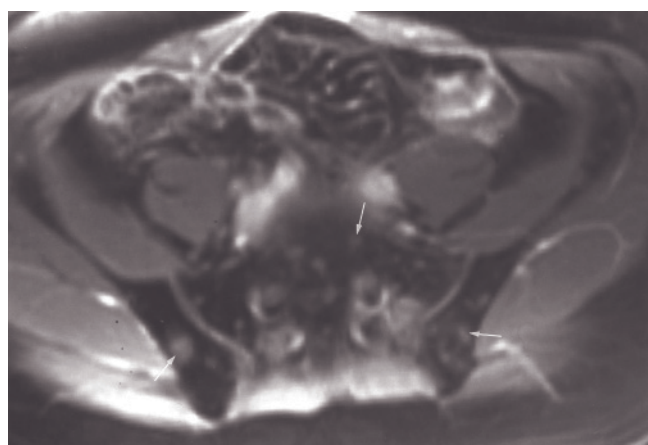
Recurrent rectal adenocarcinoma invading sacrum. Sagittal T1-weighted SGE (*a*), sagittal 512-resolution T2-weighted fat-suppressed echo-train spin-echo (*b*), and oblique coronal postgadolinium fat-suppressed SGE (*c*, *d*) images. A large recurrent tumor mass invades the sacrum and is intermediate in signal intensity on the T1-weighted image (arrow, *a*) and heterogeneously high in signal intensity on the T2-weighted image (arrow, *b*). After contrast the tumor enhances heterogeneously (open arrows, *c*, *d*) and contains an area of central necrosis (long arrow, *c*). S1 and S2 sacral segments are not involved, and uninvolved S1 and S2 nerve roots are shown (short arrows, *c*, *d*). Sparing of the upper two sacral segments is a finding on which surgeons used to base surgical resection. At surgery, the upper margin of the tumor involved S3, sparing the S2 sacral segment. Sagittal 512-resolution T2-weighted echo-train spin-echo image (*e*) in a second patient demonstrates sacral invasion by a large recurrent rectal adenocarcinoma (arrows). This tumor involves the entire sacrum and precludes a surgical resection attempt. Surgical clip from prior resection produces a signal-void susceptibility artifact (arrowhead, *e*).
